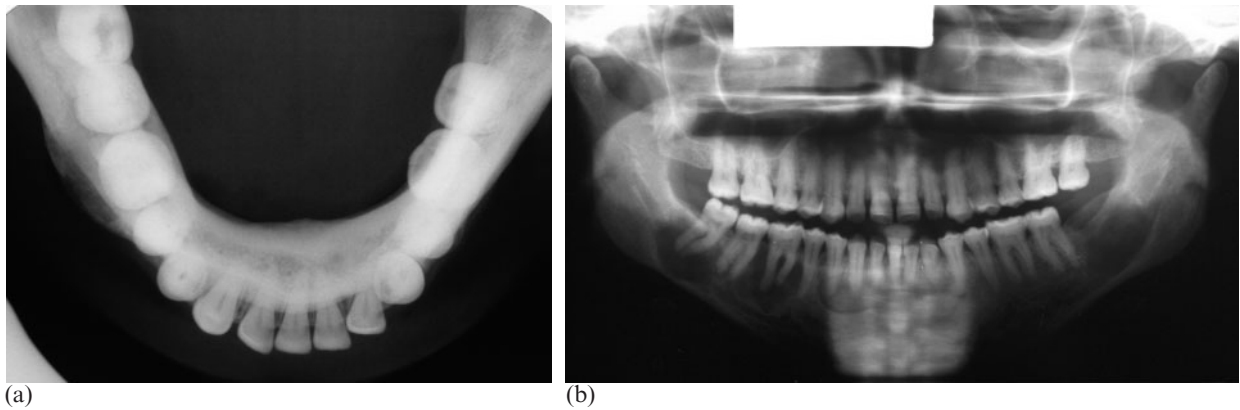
(a) Pre-treatment lower occlusal radiograph. (b) Pre-treatment orthopantomograph
